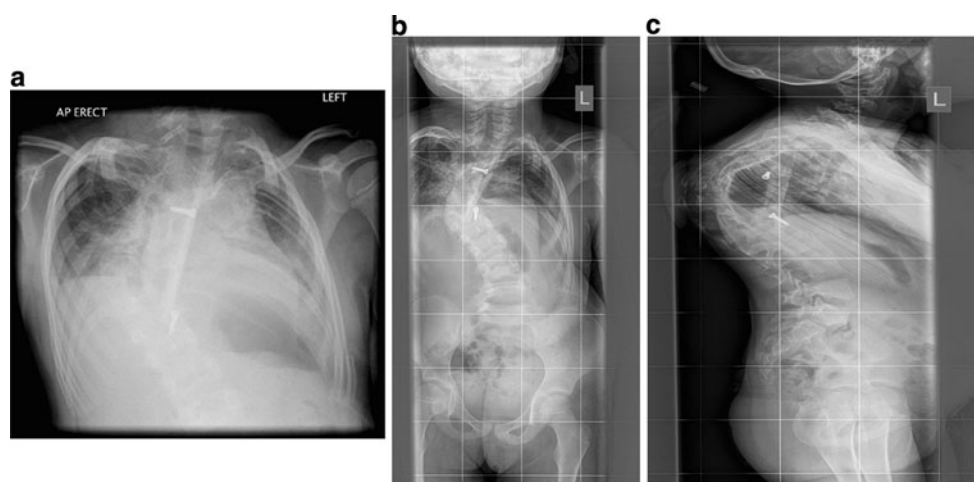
X-rays one year on showing growth in the child as well as satisfactory fixation
